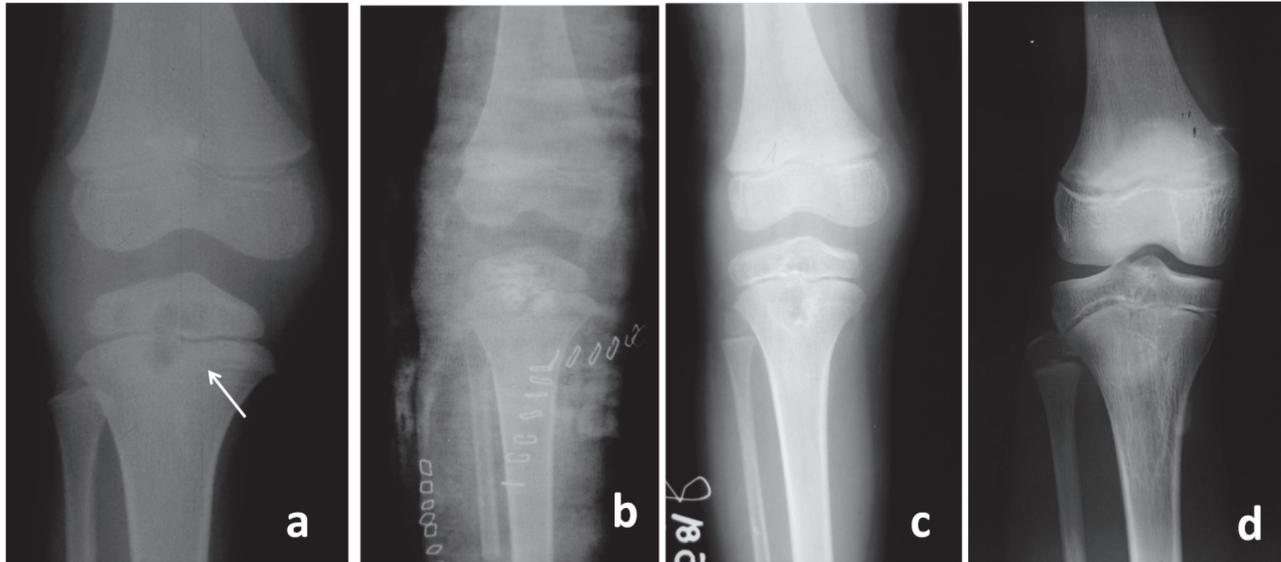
Localized transphyseal ‘hourglass’ lesion (a) Plain radiographs of knee showing hourglass (white arrow) lytic lesion in tibia with involvement of epiphysis and metaphysis transgressing physis (b) After curettage and epiphyseal bone grafting (c) Residual radiolucencies 2 years after completion of chemotherapy. Sclerosis of the margins can be appreciated indicating healing of the lesion (d) Last follow up 6 years. Some residual lucencies still persist.
